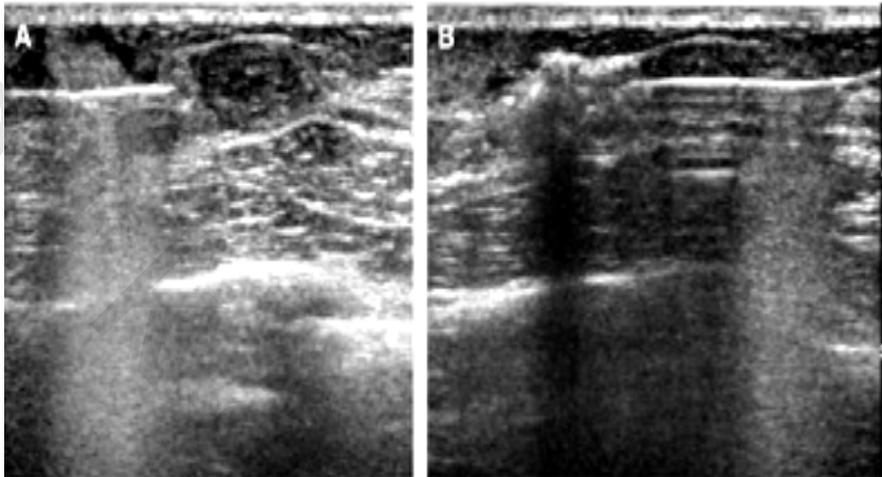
Ultrasound-guided CNB performed with an automated large core device.
